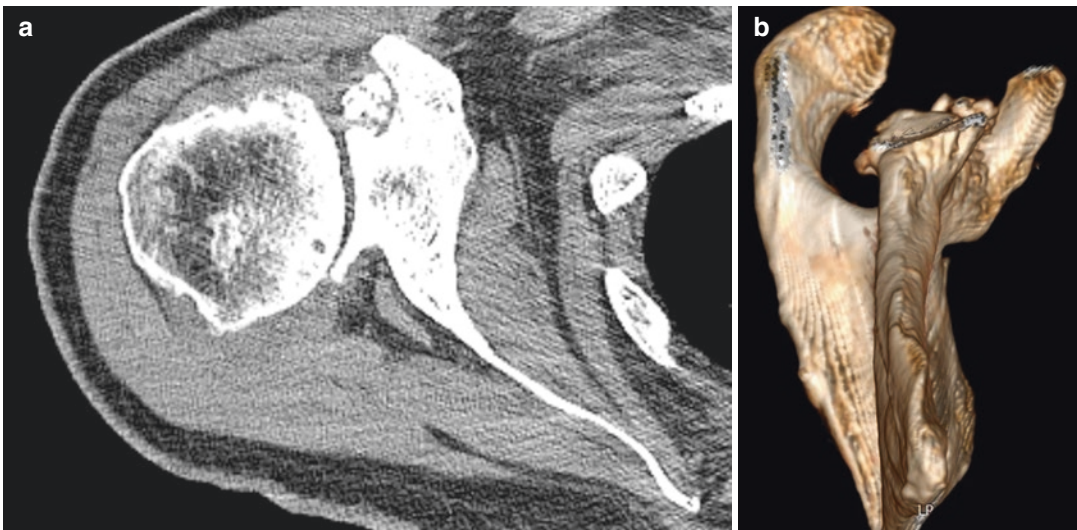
2D CT reconstructions (a) are less reliable than 3D CT reconstructions (b) in estimating the true glenoid version
